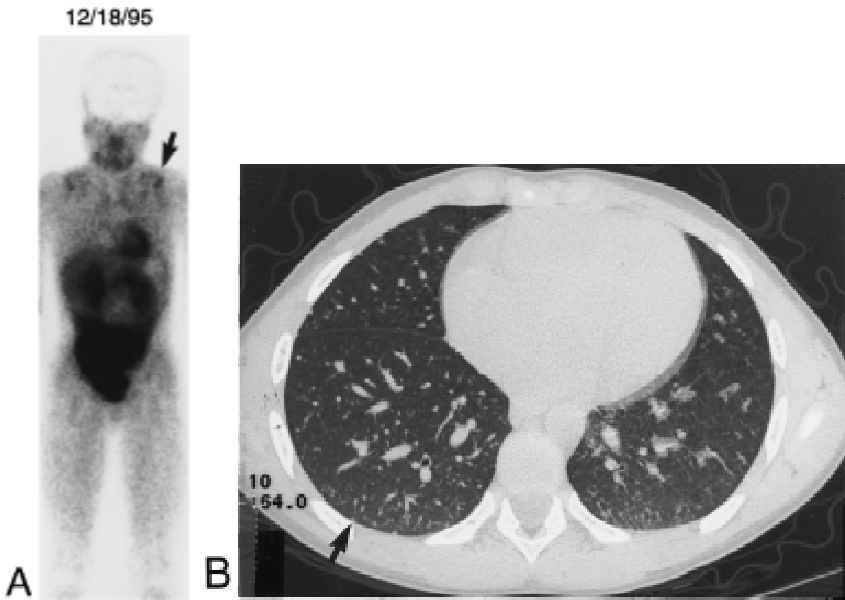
(A) ^{99m}Tc-sestamibi scan at second relapse showing uptake in the lung (arrow). (B) High-resolution chest CT at second relapse showing lung metastases (arrow).
